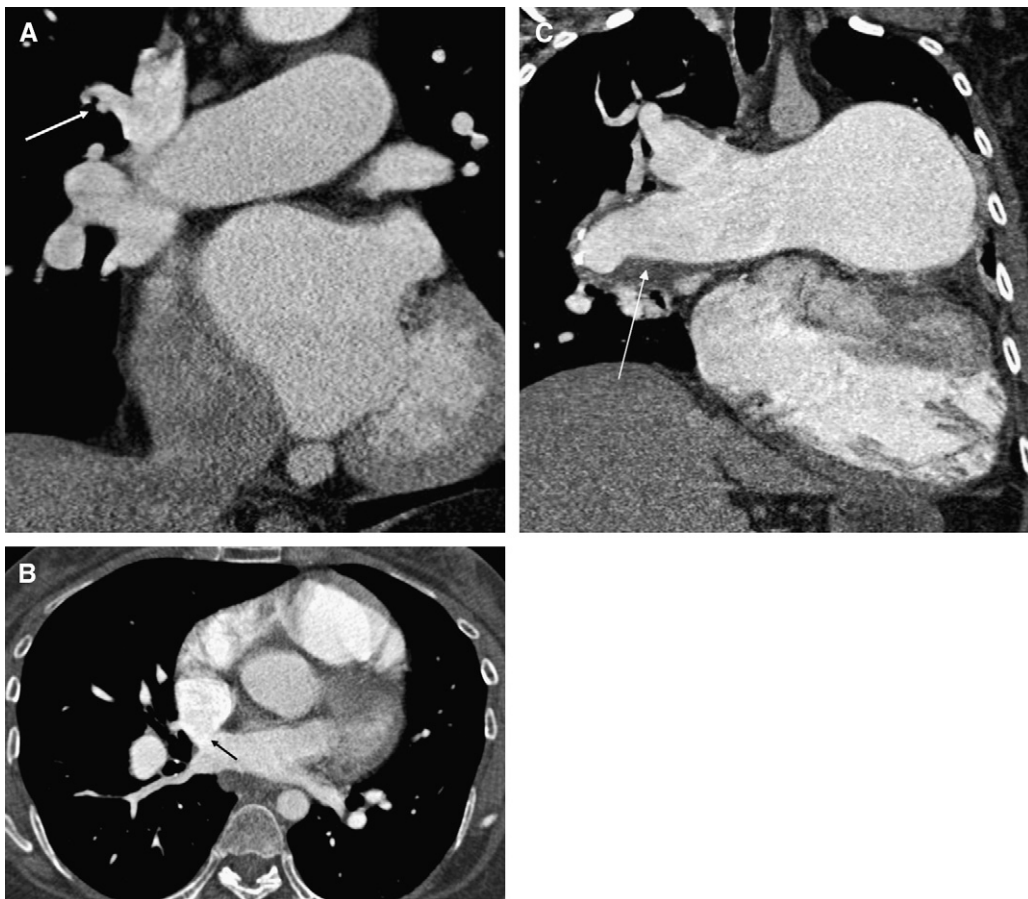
A 45-year-old woman with pulmonary hypertension. (A) Coronal reformatted CT image, showing partial anomalous pulmonary venous drainage of the right superior pulmonary vein into the superior vena cava (arrow). (B) Transaxial CT image, demonstrating an associated superior sinus venosus type atrial septal defect (arrow). (C) Coronal reformatted CT image, showing enlargement of the pulmonary artery, which contains partially calcified in situ thrombus (arrow).
